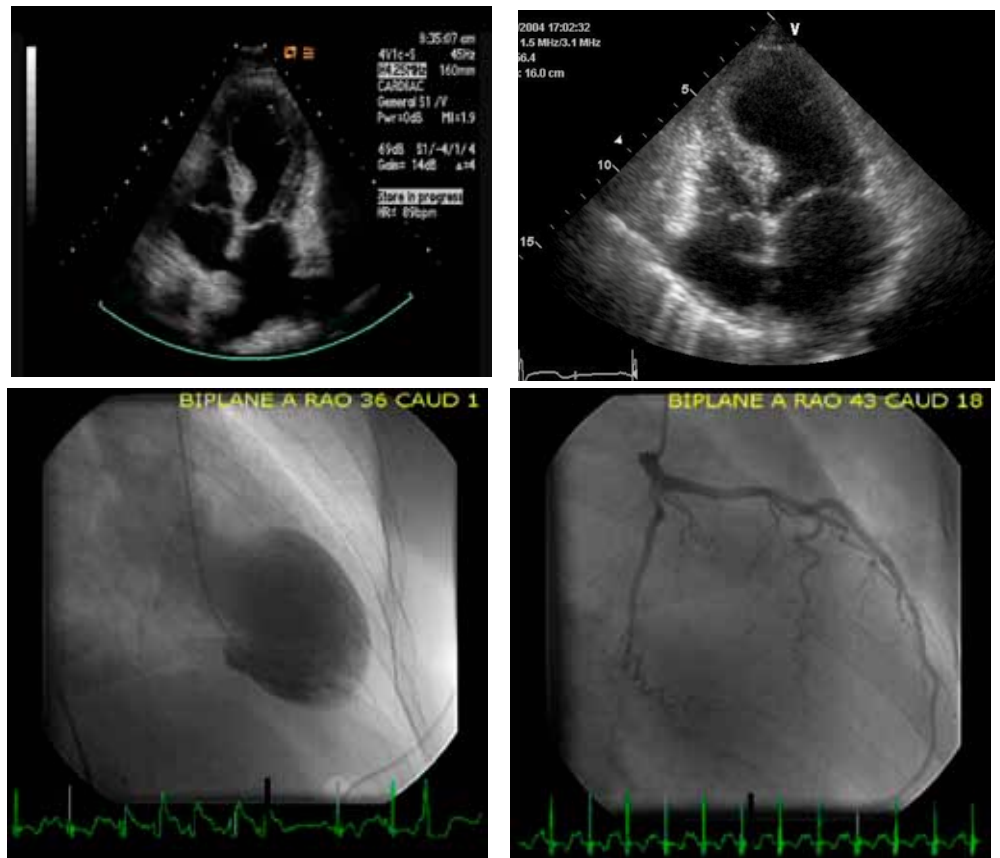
and Fig. 2. The Echocardiographic finding of transient left ventricular apical ballooning syndrome involving the left ventricular apex and mid-ventricle in the absence of obstructive epicardial coronary disease.
